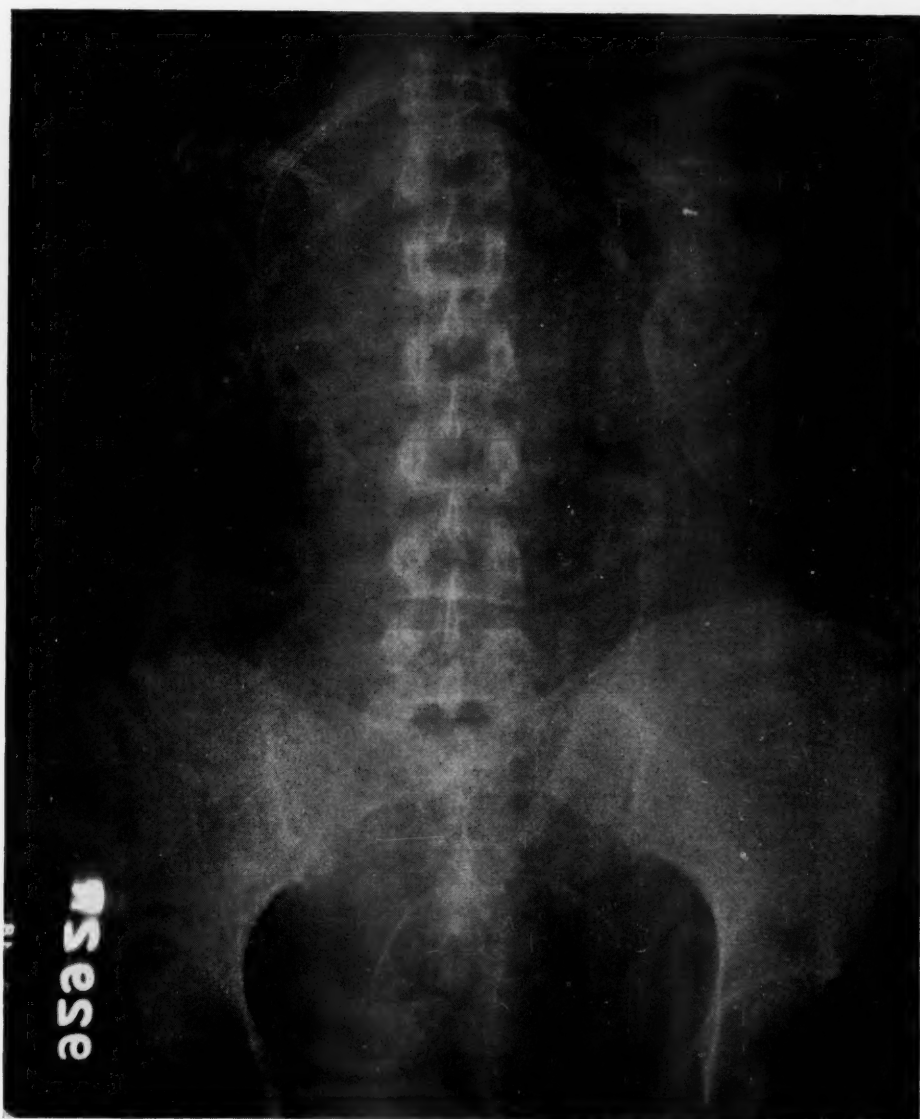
X-ray of quadruplet pregnancy at about twenty-eight weeks.
